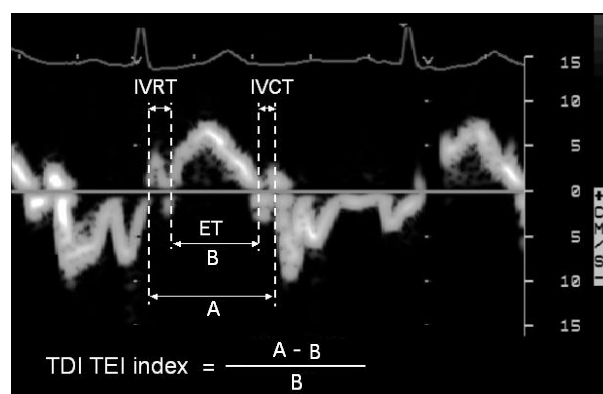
A representative case of measurements for calculation of the TDI-Tei index. IVRT: isovolumetric relaxation time, IVCT: isovolumetric contraction time, ET: ejection time, TDI-Tei index: tissue Doppler image derived Tei index.
